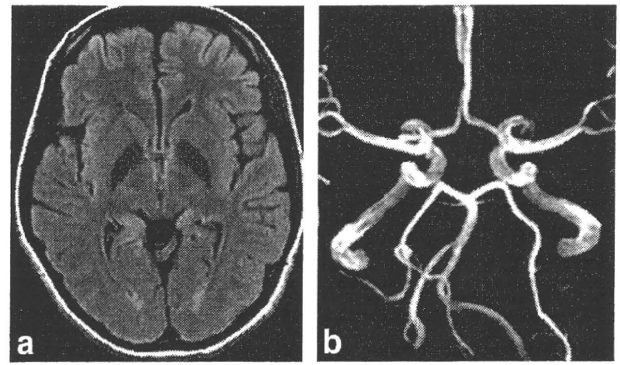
After methylprednisolone pulse therapy, FLAIR imaging on MRI demonstrated that high intensity signals in the occipital lobes were improved (a). MRA demonstrated that vasoconstriction of posterior cerebral arteries was also improved (b).
